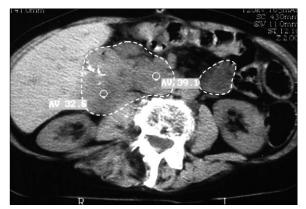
The CT scan at the level of liver, showing polycyclic tumor (106 x 54 mm) with sings of necrosis. Smaller tumor was found below the lower pol of left kidney (40 x 45 mm). The visible cyclic metastases at the liver and below the kidney are encircled on the picture shown above.
